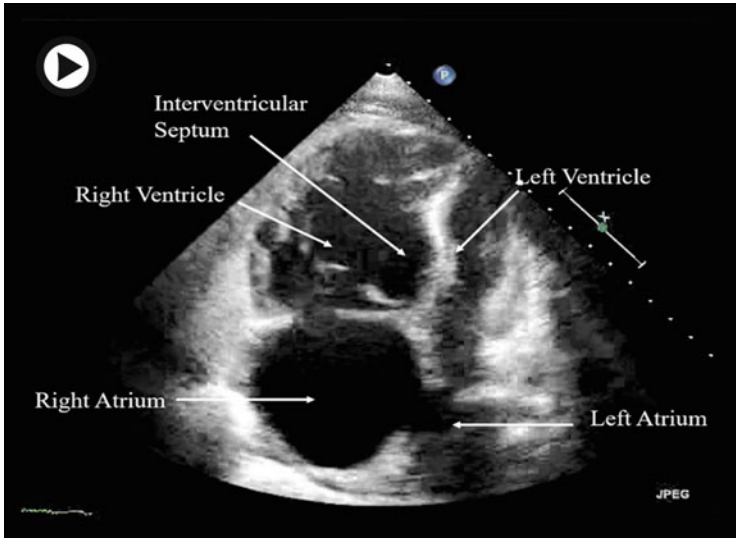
(Video 4.6) Apical 4 chamber video of the heart in a patient with a large pulmonary embolism. Note the enlarged right ventricle relative to the left ventricle causing the interventricular septum to be pushed into the left ventricle. The right atrium is also enlarged (▶ <https://doi.org/10.1007/000-7pt>)
